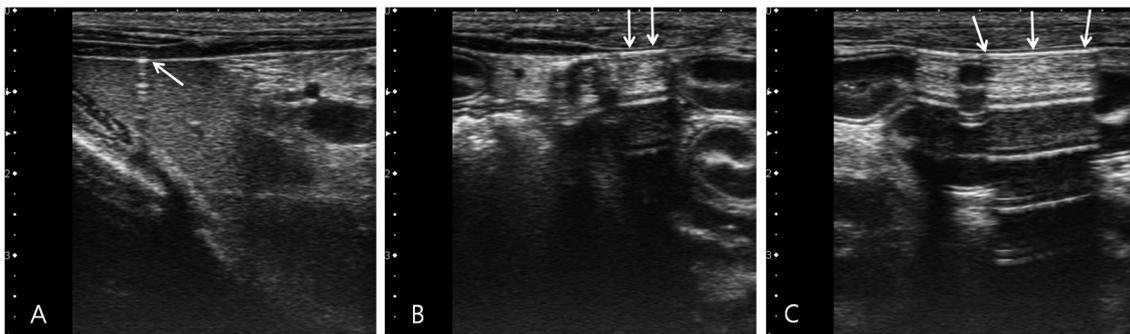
Ultrasonographic images in sagittal orientation in the left lumbar (A) and umbilical region (B, C) show extraluminal air inducing linear enhancement and thickening of the peritoneal stripe sign (EPSS) associated with either dirty shadowing or reverberation artifacts (arrows). As injected air was added in increments (A: 0.1 ml, B: 0.2 ml, C: 0.4 ml), EPSS size was relatively increased. These results indicate that an increase in the EPSS size reflects an increase in the total extraluminal air within the abdominal cavity.
